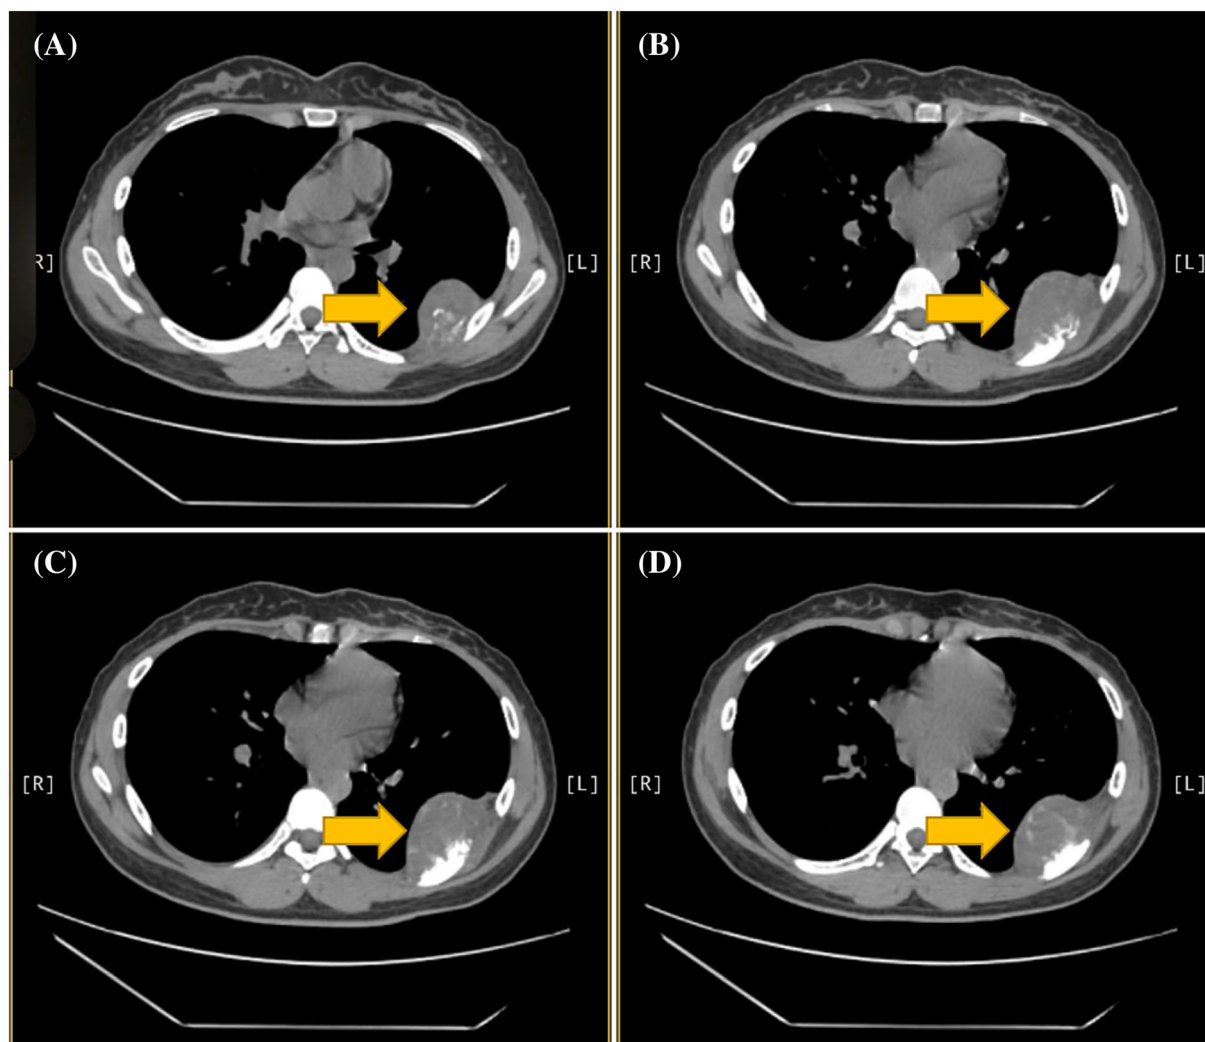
Preoperative CT showed destruction of the seventh rib and surrounded by mass (pointed by yellow arrow).
